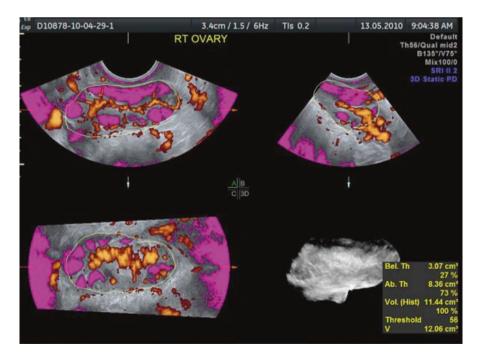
3D ultrasound of the ovary with threshold volume used to calculate the stromal volume. On the right lower corner, in the calculation box, the figure that says above threshold indicates the stromal volume
